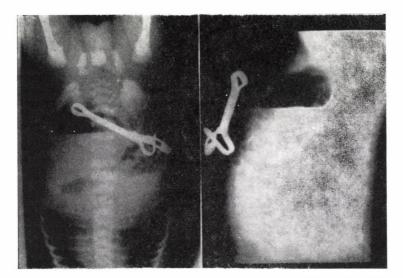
Plain roentgenogram showing large air-fluid level (Case 1)
